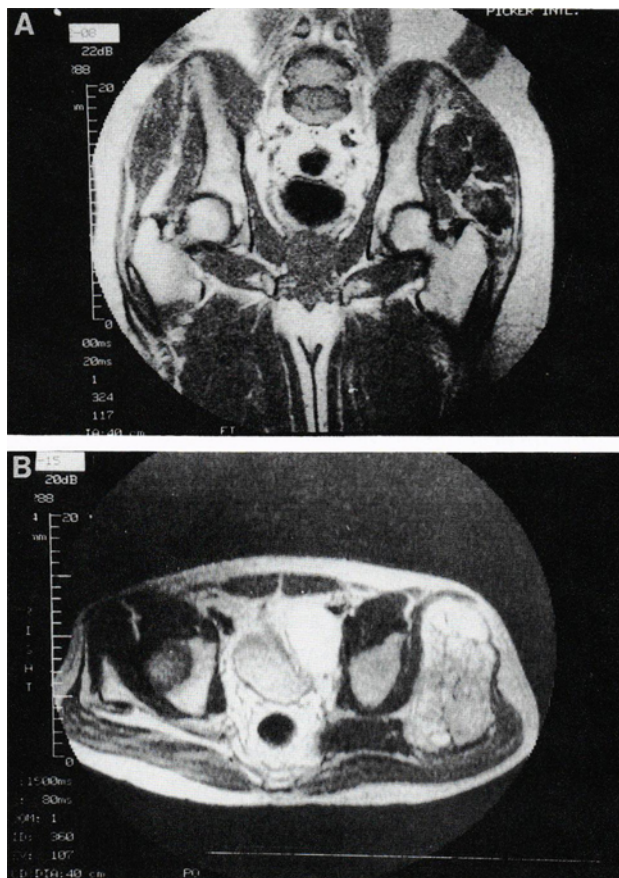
(A) A coronal cut from the MRI scan shows a multilobulated mass in the gluteal region, extending close to both iliac bone and proximal femur. (B) An axial cut from a T1 weighted MRI scan also shows the extensive left gluteal mass.
